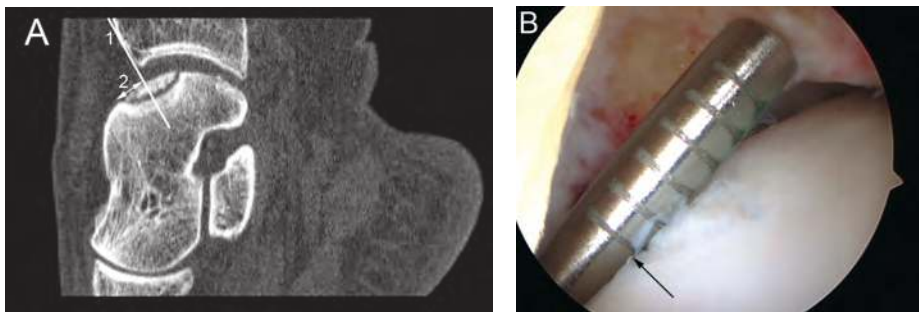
Analysis of a patient with a centromedial OCD. (A) On the CT scan, a tangent line (1) of the anterior distal tibial rim was drawn perpendicularly to the talar dome. The distance (2) from the anterior border of the OCD to this line was measured. (B) During arthroscopy, the distance between the anterior distal tibial rim and anterior border of the defect (arrow) was measured with a specially developed arthroscopic ruler. On this ruler, the first line is 2 mm from the tip and each following line is 1 mm more from the tip, up to 7 mm.
